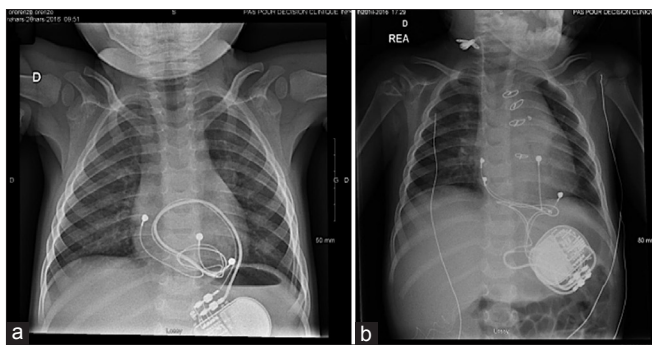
(a) Preoperative posteroanterior chest radiograph showing a looping by the atrial and ventricular leads, evoking a cardiac strangulation. (b) Posteroanterior chest radiograph postlead replacement, showing patient clear of any possible cardiac strangulation with the leads well situated on the diaphragmatic surface of the pericardium
